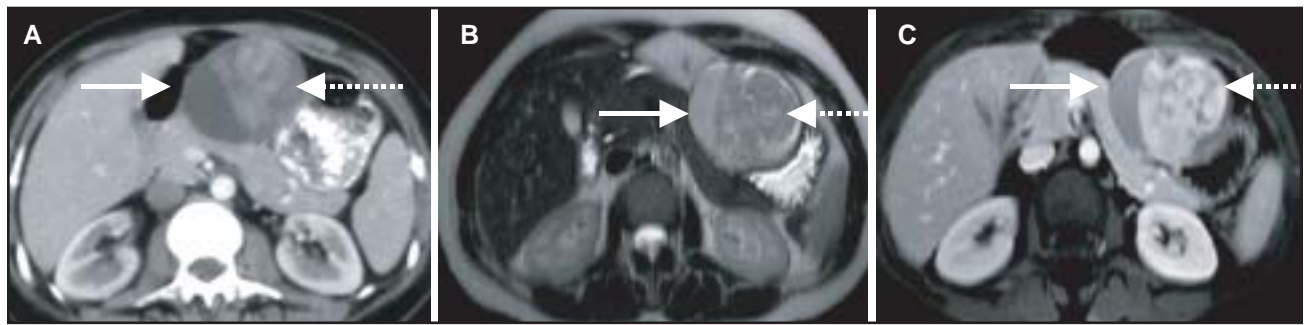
Gastric GIST. (A) CT demonstrates an exophytic mass with a well-defined margin, heterogeneous contrast enhancement (dotted arrow), and a homogeneous low-density area without enhancement (solid arrow). (B) T2-weighted MRI without contrast enhancement demonstrates an exophytic mass with a well-defined margin, heterogeneous signal in the area of CT contrast enhancement shown in (A) (dotted arrow), and a homogeneous higher signal region (solid arrow). (C) T1-weighted MRI with gadolinium contrast enhancement demonstrates heterogeneous enhancement (dotted arrow), corresponding to the area of CT enhancement shown in (A), and homogeneous low-density region without enhancement (solid arrow), also corresponding to the CT shown in (A).
